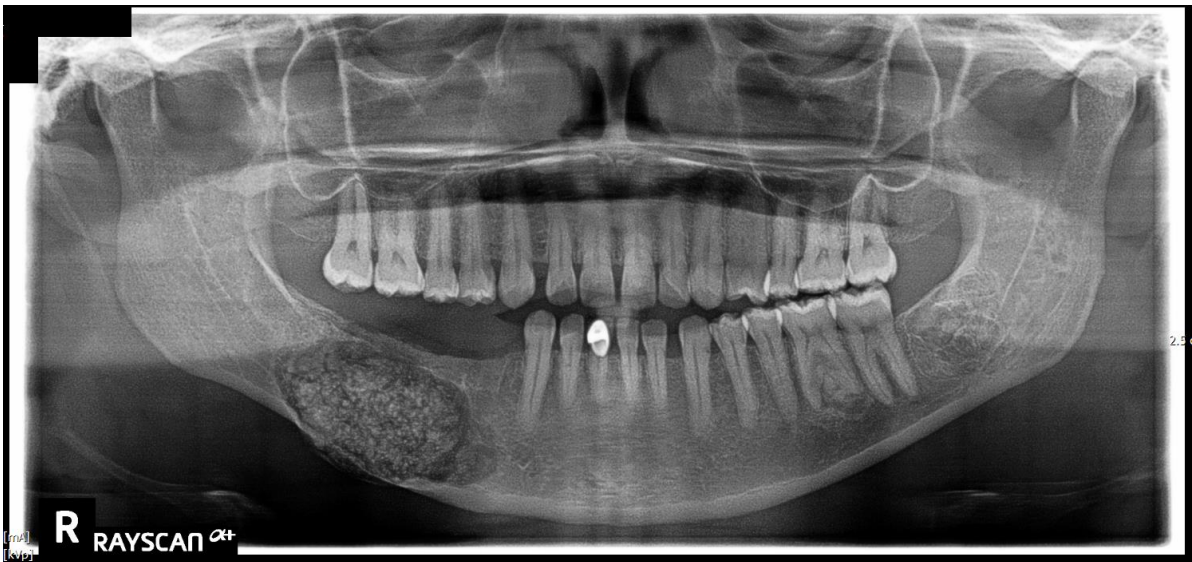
Panoramic radiograph obtained prior to surgical resection of lesion.
